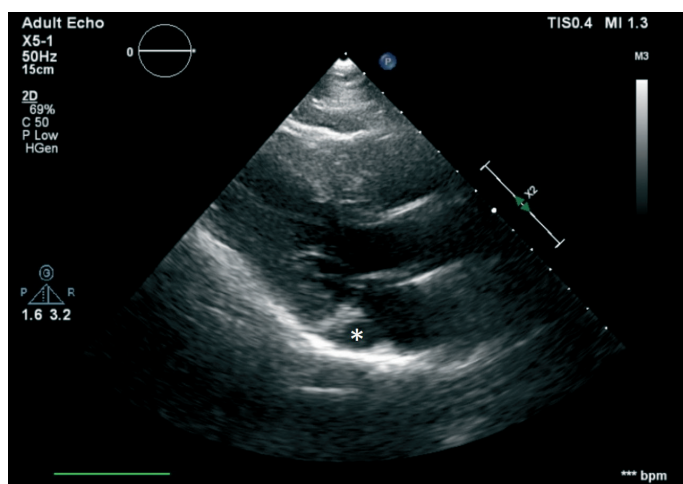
The dilated coronary sinus (asterisk) in the parasternal long-axis view (transthoracic echocardiography)
